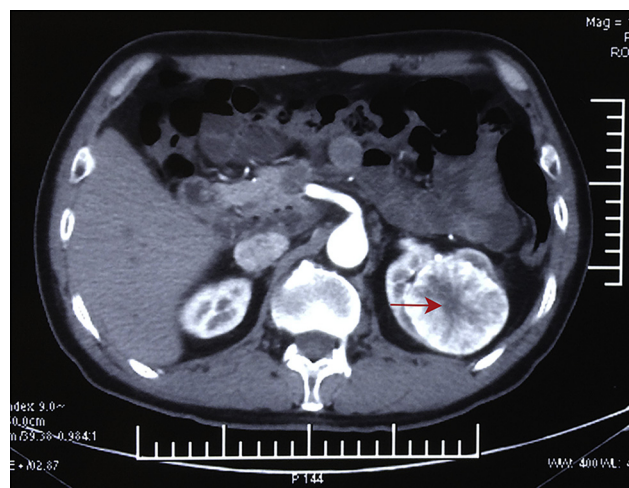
The computerized tomography (CT) appearance of the tumor showing central low density spoke-wheel-like shape (arrow) during corticomedullary phase.
